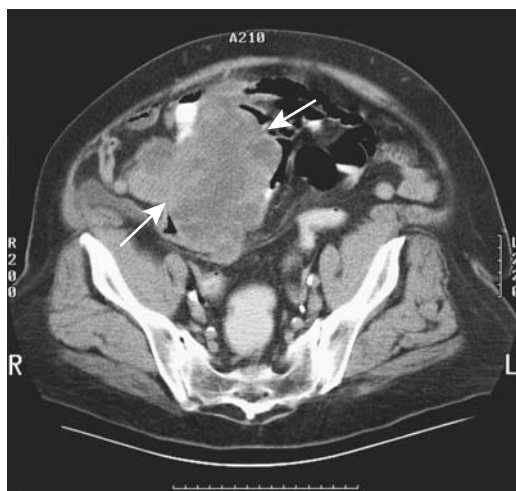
Small bowel leiomyosarcoma, probably a gastrointestinal stromal tumor (GIST), in a 47-year-old woman with fever, pain, and a palpable right lower quadrant tumor. Oral and IV contrast-enhanced CT reveals a complex, heterogeneously enhancing tumor (arrows). Other images identified surrounding mesenteric infiltration. (Courtesy of Patrick Fultz, M.D., University of Rochester.)
